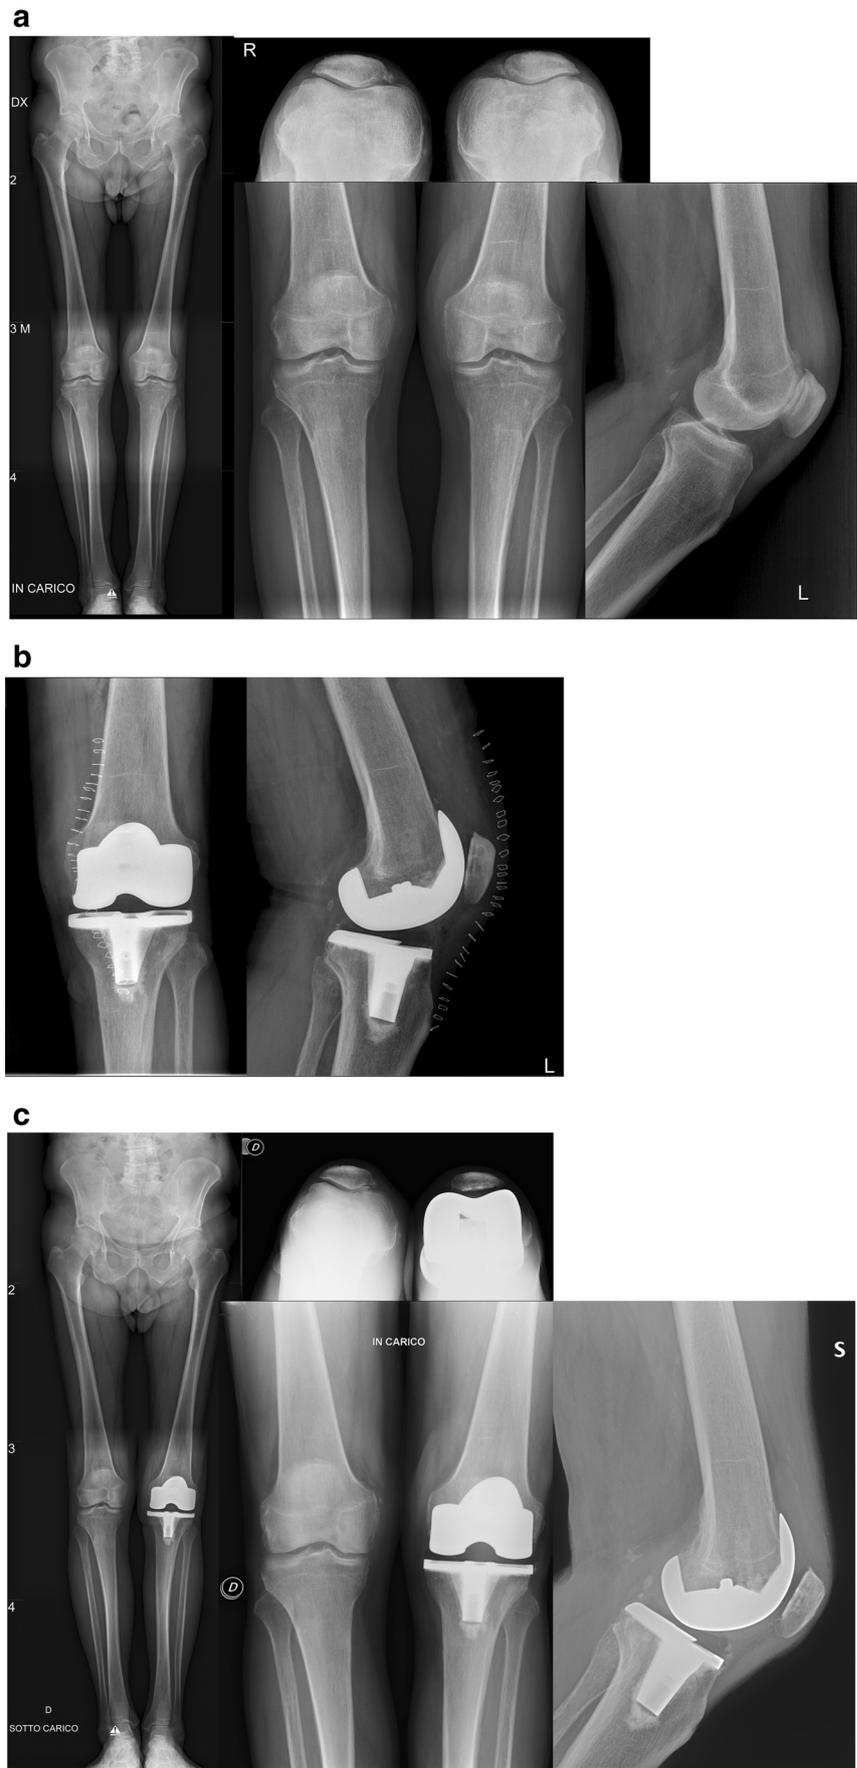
Male, 78 years old. Pre-operative X-rays (a), post-operative (b), and follow-up at 3 years (c)
